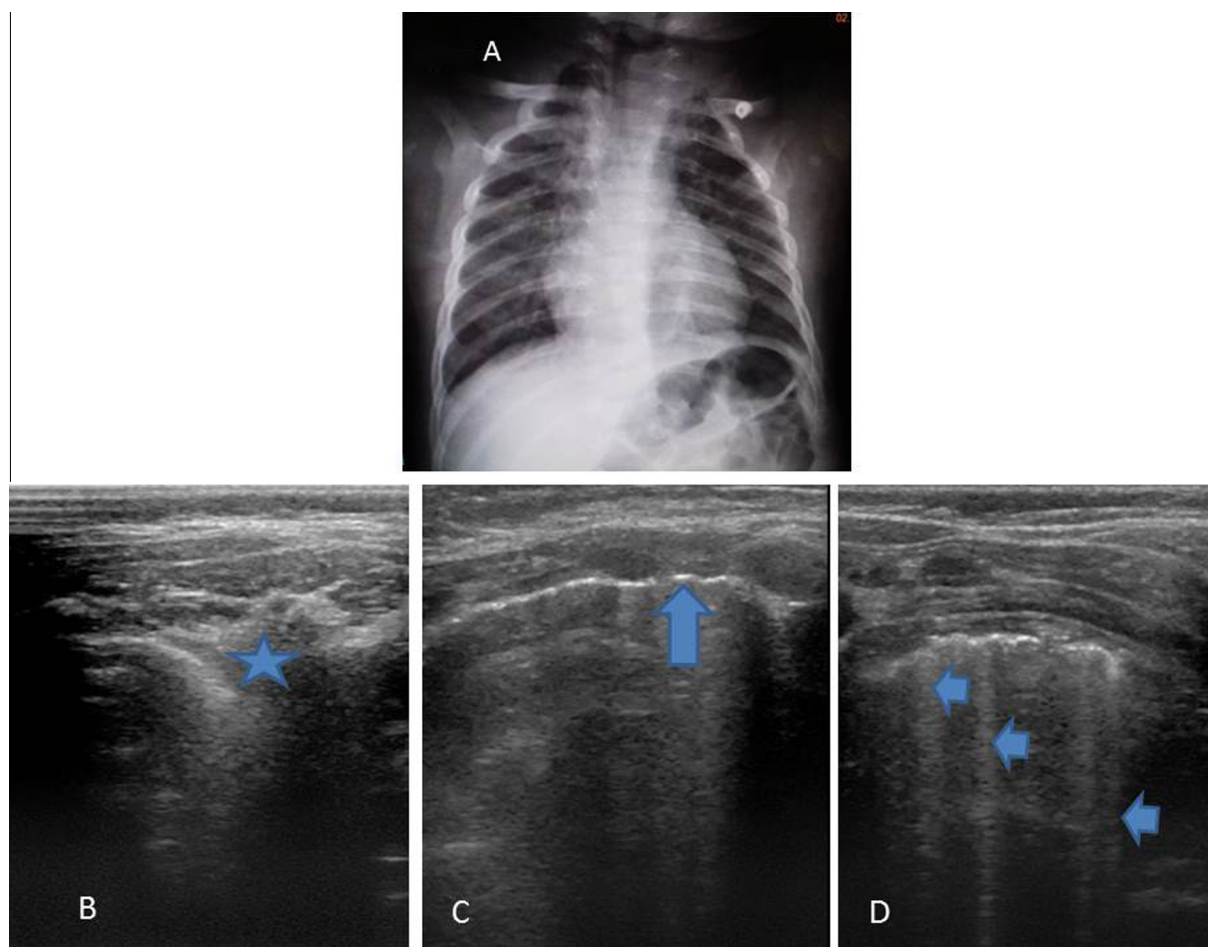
A – Chest X-ray of 5 months-old infant with moderate bronchiolitis revealed increased bronchovascular markings and hyperinflation of both lungs. B – Lung ultrasound showed evidence of small tissue echogenic area sub-pleural in location mostly representing early consolidating area (star). C – It shows extensive pleural line irregularity clearly detected (arrow). D – Here, the horizontal arrows refer to the hyperechoic shadow of compact B lines on Rt. lung.
